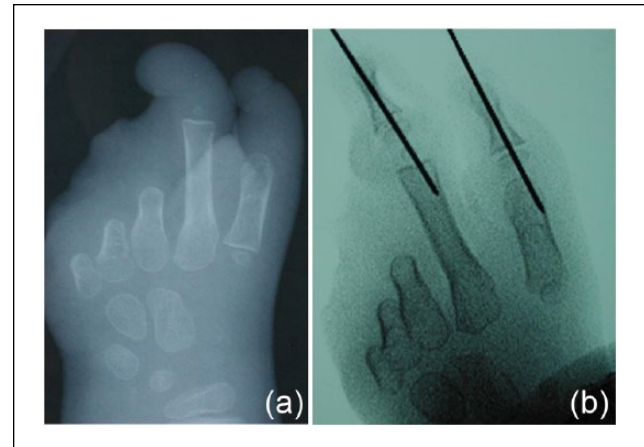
(a) Preoperative and (b) postoperative radiographs of nonvascularized toe phalanx transfers.
